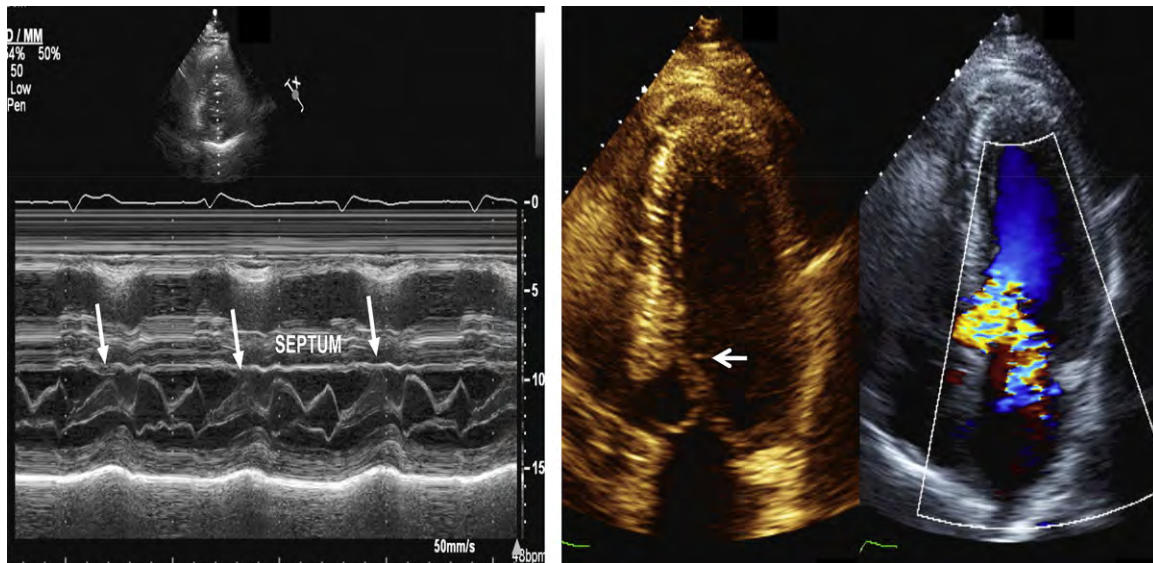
(Left) M-mode recording of SAM and mitral leaflet septal contact (*arrows*). (Right) SAM on 2D echocardiography (*arrow*). In the same panel, color Doppler shows the high velocities across the LVOT in mosaic color and the eccentric mitral regurgitation jet that is directed posterolaterally.
